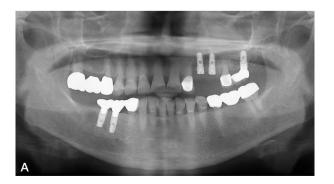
A: Panoramic radiograph at first visit(2013/03). B: Intraoral photograph at first visit(2013/03) C: Intraoral photograph during surgery(2013/05)
